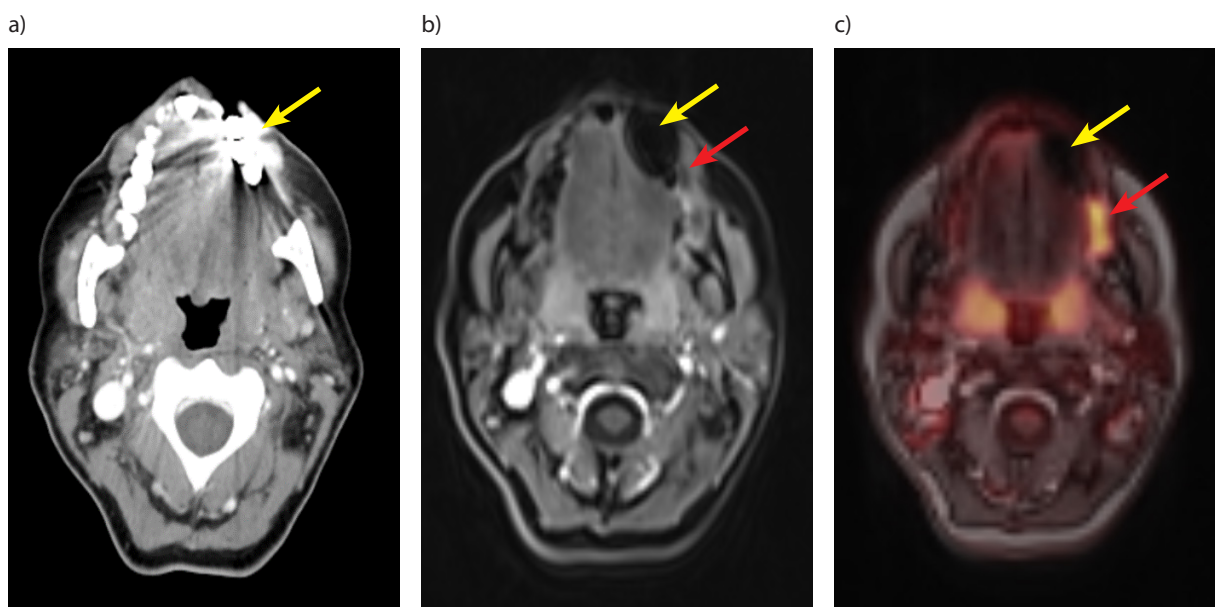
An artifact in imaging examinations. An artifact (yellow arrows) from amalgam tooth fillings in the CT (a), MR (b) and PET/MR (c) images, making it difficult to diagnose lower gingiva lesions on the left side (red arrows)
